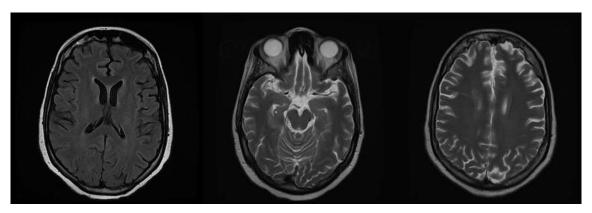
Axial FLAIR MRI and Axial T2 weighted MRI at four months post-op (i.e. most recent neurology follow-up). Note complete resolution of T2 hyperintensity and FLAIR signal in right hemisphere compared to the images on post-op Day 2.
